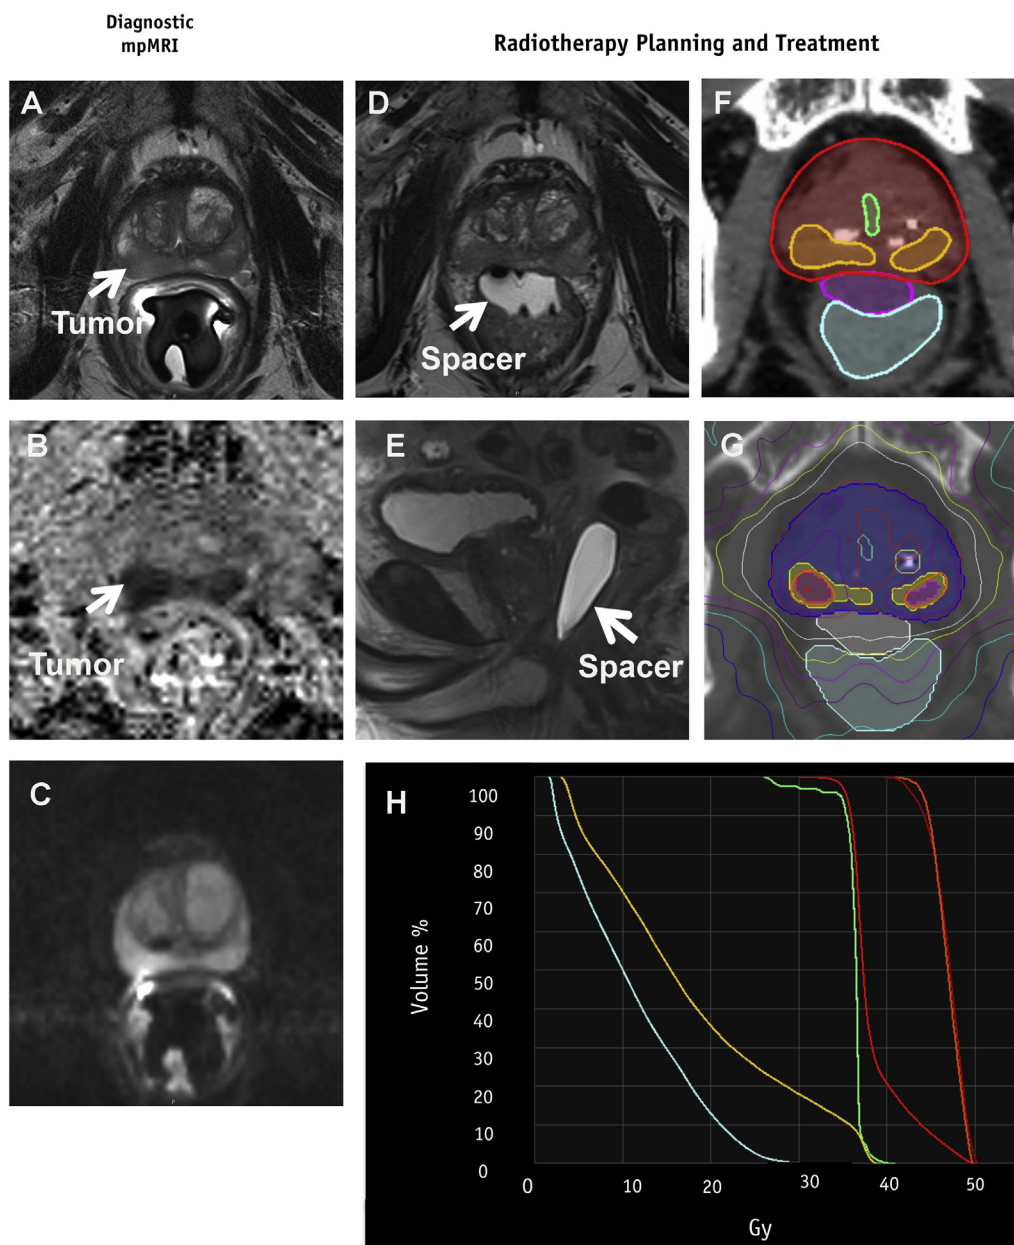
Patient with a prostate cancer (T2, N0, M0; Gleason Score, 3 + 4 = 7; prostate-specific antigen, 20 $\mu\text{g/L}$). Magnetic resonance imaging shows 2 lesions in the medial region, in the right and left posterior peripheral zones, with hypointensity on axial T2-weighted image (A), restriction of diffusion on apparent diffusion coefficient map (B) and on diffusion-weighted images (C), and Prostate Imaging Reporting and Data System (4 on the left and 5 on the right). RT planning magnetic resonance imaging scan shows a hyperintense rectal spacer on the axial (D) and sagittal (E) T2-weighted images. (F) RT planning was performed on a CT scan, and an axial image shows the RT volumes: prostate in red, tumor in yellow, rectal spacer in pink, rectum in light blue, and urethra in green. Fiducial markers were placed in the prostate for robotic-assisted tracking purposes. (G) Stereotactic body radiation therapy plan using CyberKnife. The whole prostate was treated with 36.25 Gy in 5 fractions of 7.25 Gy (dark-blue isodose) with a boost of 47.5 Gy to the dominant intraprostatic nodule (orange isodose). (H) Dose-volume histogram shows the maximal dose delivered to the urethra: 0.1 cm^3 = 38 Gy (light-green curve); the anterior rectal wall, 1 cm^3 = 25.9 Gy (light-blue curve); and the bladder: 1 cm^3 = 38 Gy (yellow curve). The prostate (red curve) and the tumors (orange curve) received the prescribed dose. *Abbreviations:* CI = computed tomography; RT = radiation therapy.
